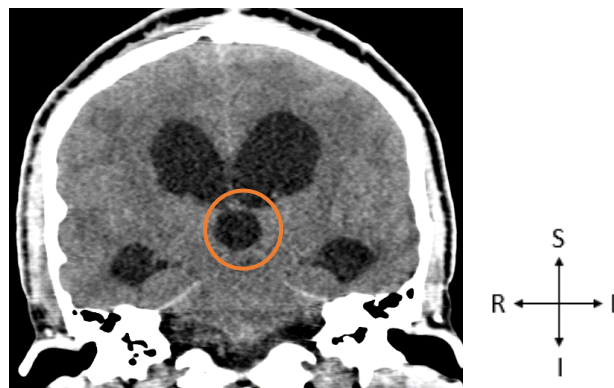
A CT scan of the brain in the coronal view, indicating the third ventricle shape. Image taken from the GSH PACS (20 October 2023). S - Superior, R - Right, I - Inferior, L - Left.
